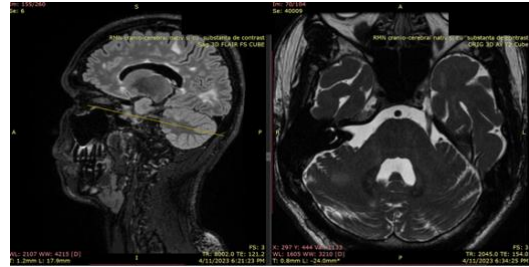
Third non-specific patient, recent MRI. Multiple typical MS lesions at the supratentorial & infratentorial level - periventricular, subcortical and cerebellar white matter. Active, contrast-enhanced cerebral lesions. Source: Author's elaboration.
